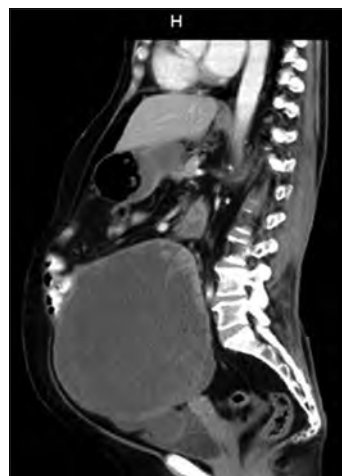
Contrast enhanced CT sagittal reconstruction images showing large hypodense lesion suggestive of malignant ovarian tumor
